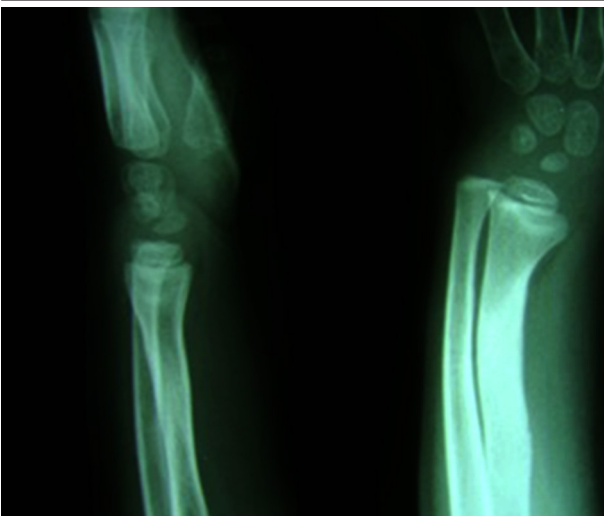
Radiography of the Wrist After 24 Months, Case No. 1
